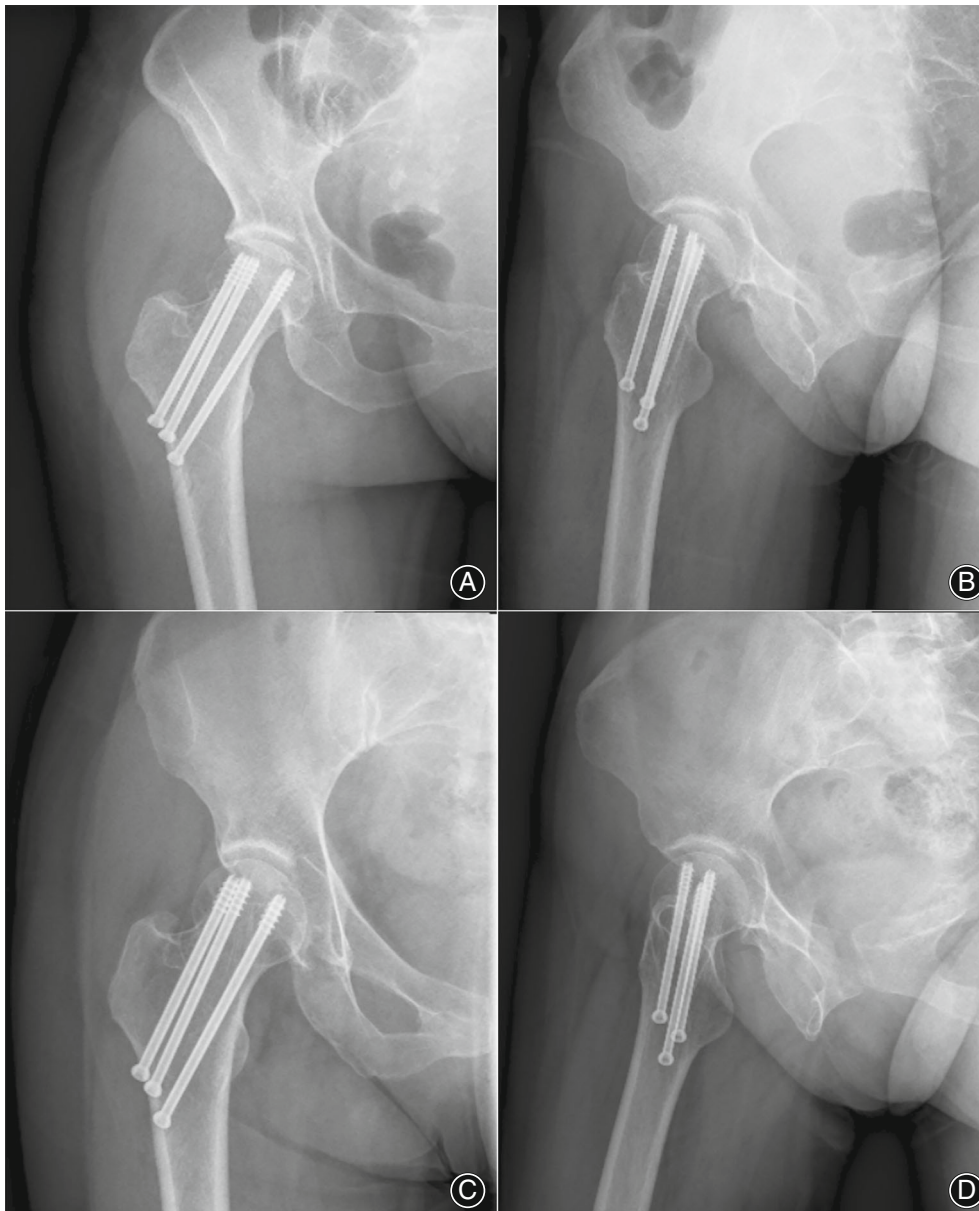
Images of postoperative radiographs within 24 h (A and B) and at 24 months after surgery (C and D) showing a case (female, 63 years old) of valgus-impacted femoral neck fracture achieving anatomical reduction and union
